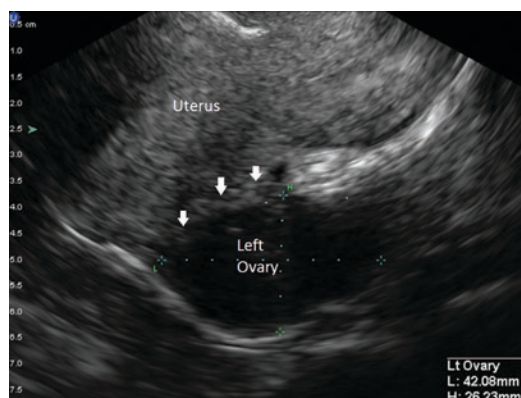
Transvaginal sonography (TVS) image in the sagittal plane, displaying the left ovary fixed to the posterior uterine fundus; the white arrows indicate the adhesion site. The ovarian sliding sign was negative in this region during the TVS assessment, i.e. the left ovary did not glide smoothly across the posterior uterine fundus
